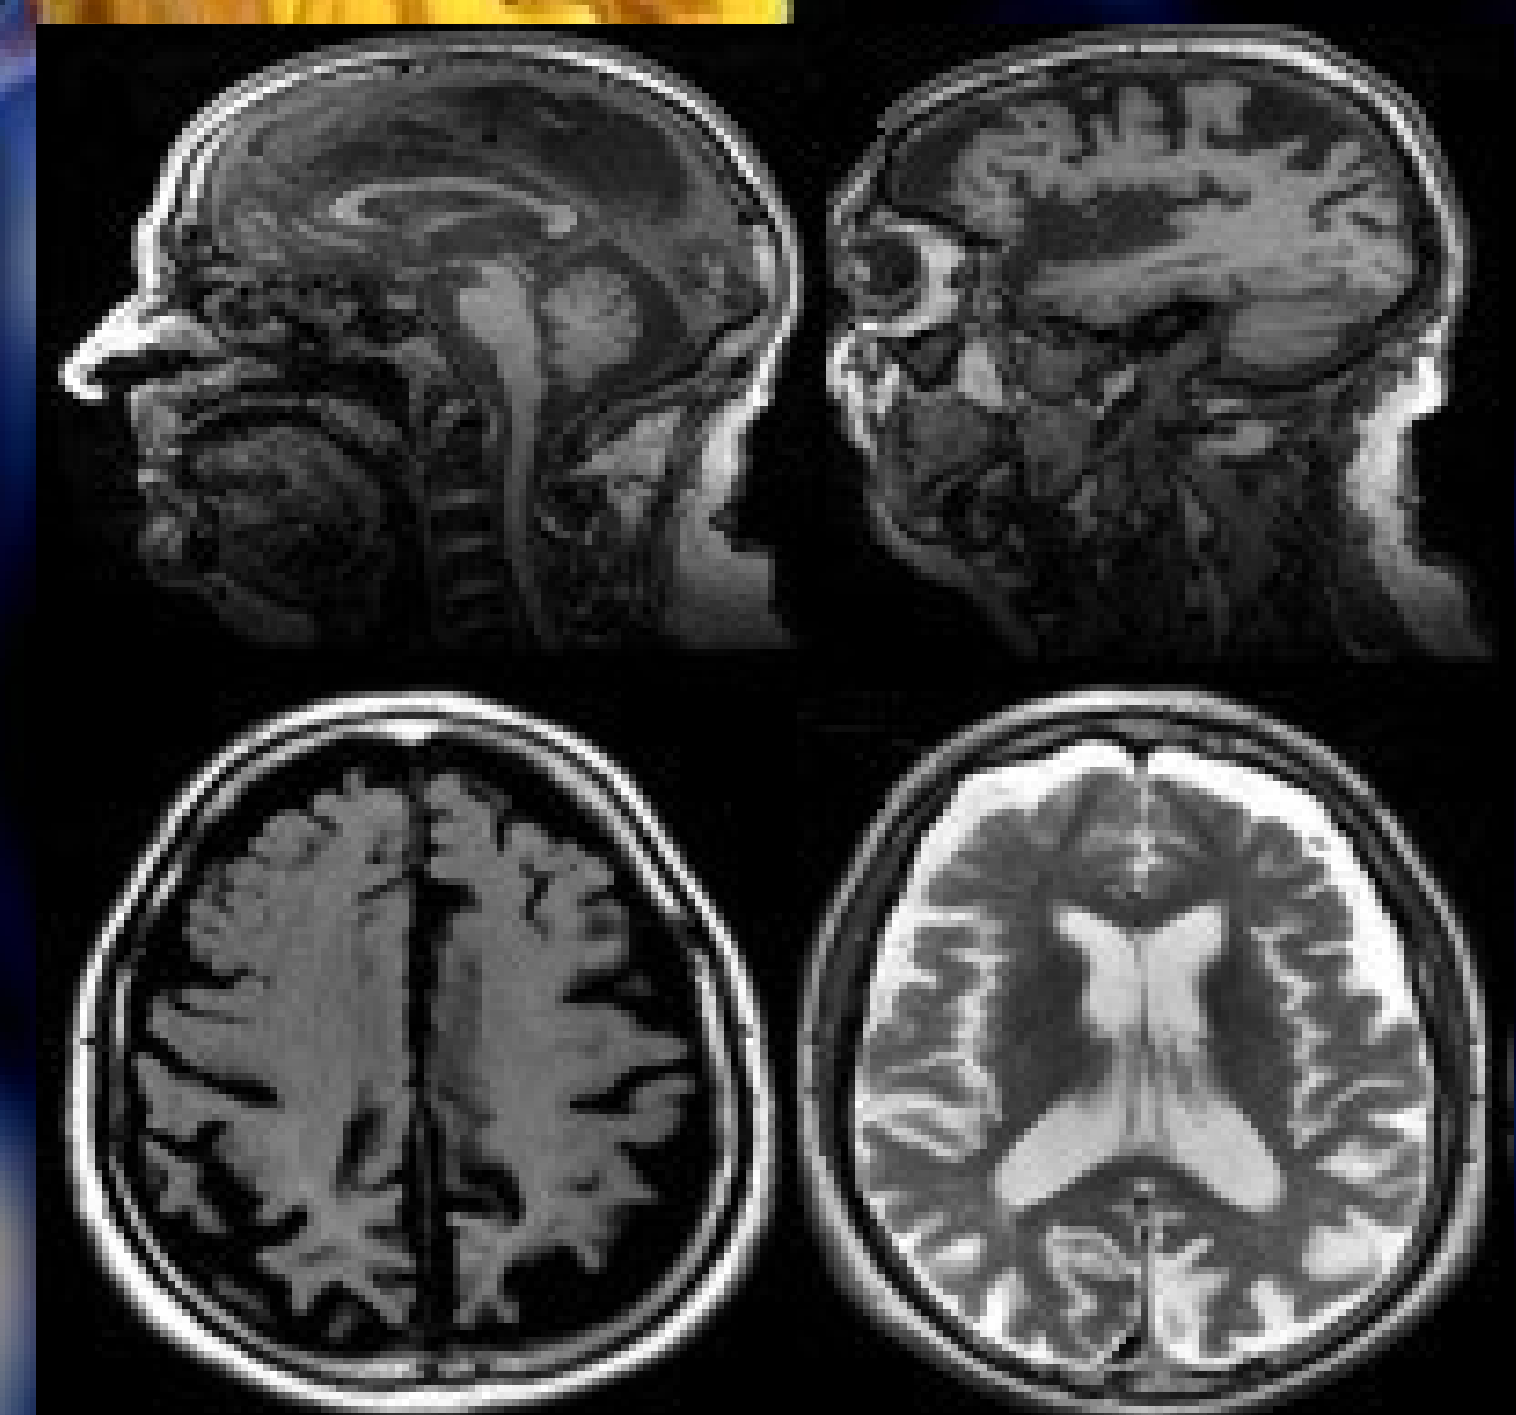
3T MR imaging sequences of the brain showed severe atrophy in the frontal and temporal lobes
